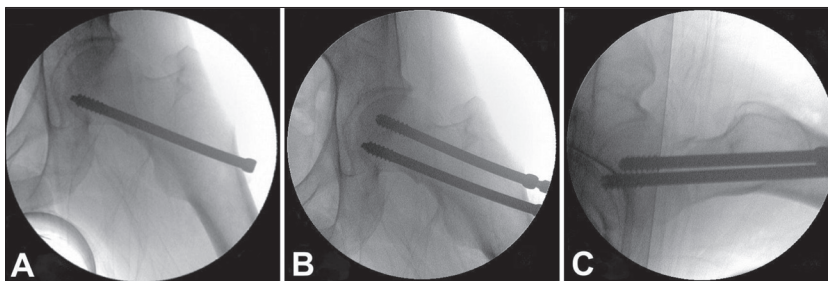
Plain radiographs to verify correct placement of self-tapping cannulated screws femoral neck fixation (A – distal screw placement; B – proximal screw placement; C – profile parallel placement)
